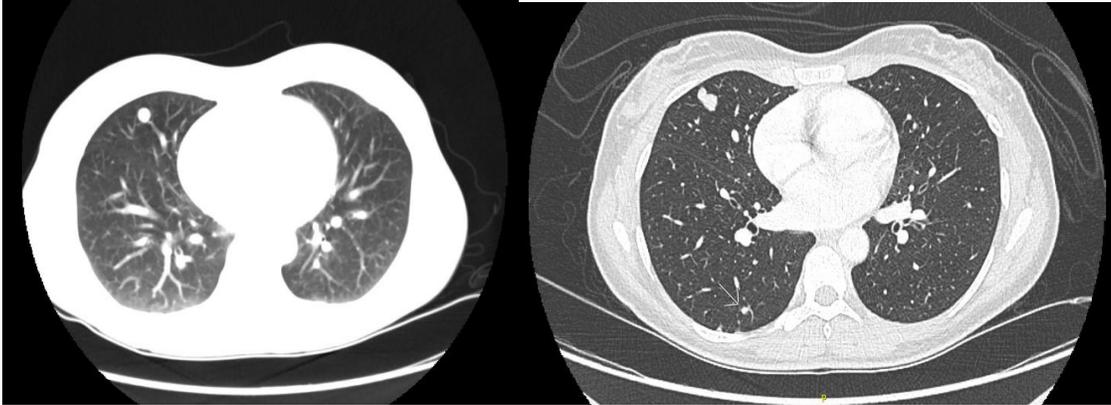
Initial CT scan chest with contrast shows bilateral multiple lung nodules.
